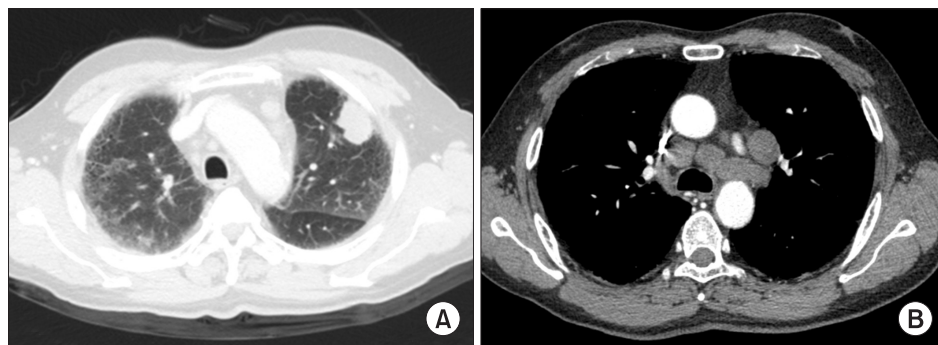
(A) Chest computed tomography (CT) in May 2012 showing a 3.2×2.3 cm mass in the left upper lobe. (B) The same CT showing enlargement of multiple mediastinal lymph nodes.
